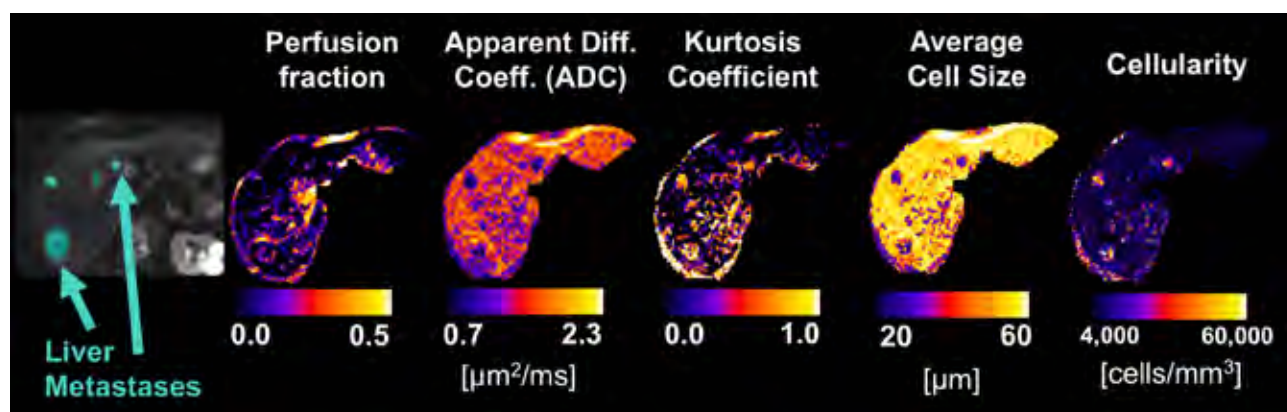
DW microstructural MRI metrics provide biological-specific metrics that offer sensitivity to tumorigenic processes in the liver such as metastases.
